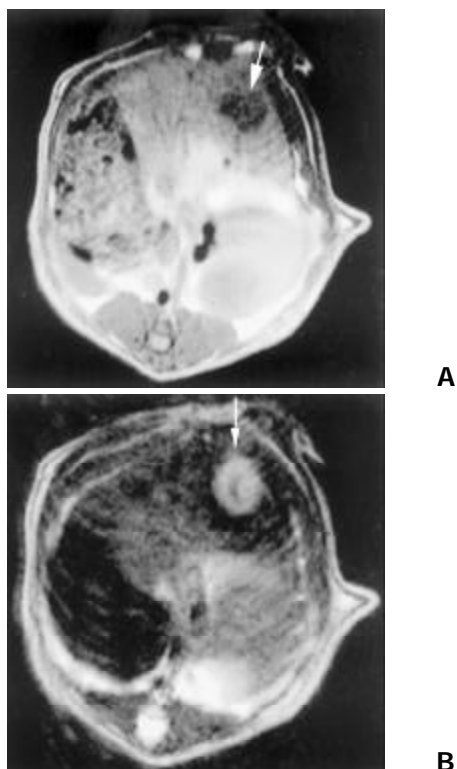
14 days after the implantation, tumor center showed lower intensity on T1 (A) and T2-weighted (B) than that of periphery, which indicate coagulation necrosis
